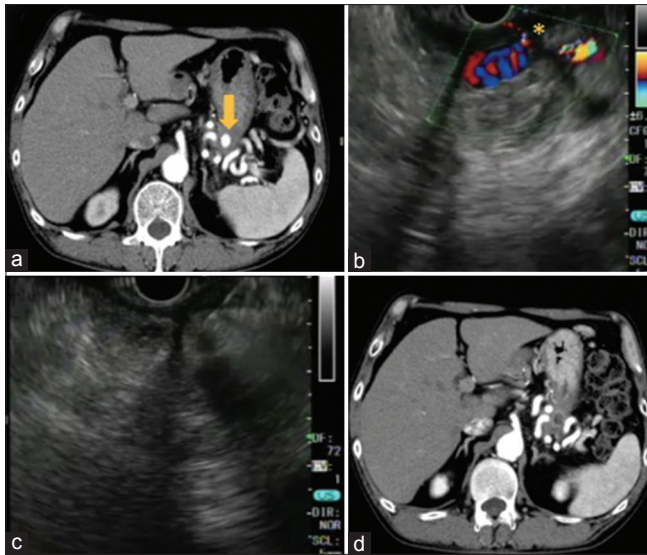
(a) Computed tomography scan showed left gastric artery pseudoaneurysm (yellow arrow) without any visible feeder artery in the gastric wall. (b) EUS targeted left gastric artery pseudoaneurysm from the posterior side of stomach. Small-caliber feeder artery(*) was identified on color Doppler. (c) 1.0 mL histoacryl was injected and became solidified in the pseudoaneurysm, instantly showing dense acoustic shadow on EUS. (d) Computed tomography scan revealed complete embolization of the pseudoaneurysm in 2 months
